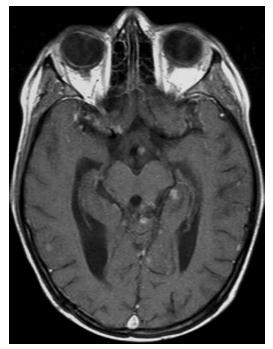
Case 8. Axial Gd-enhanced MR image obtained in a 12-year-old boy showing leptomeningeal dissemination of the embryonal carcinoma component of a mixed, malignant, secreting intracranial GCT.
